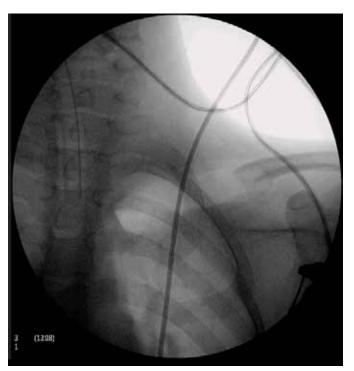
Postoperative X-ray showing a radiopaque area corresponding to the excision of the medial portion of the clavicle
